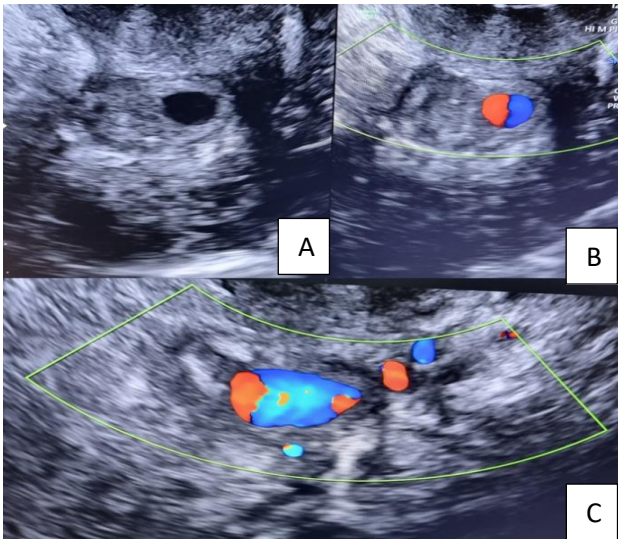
(A-C): Ultrasound and Doppler images of the uterine artery pseudoaneurysm.
